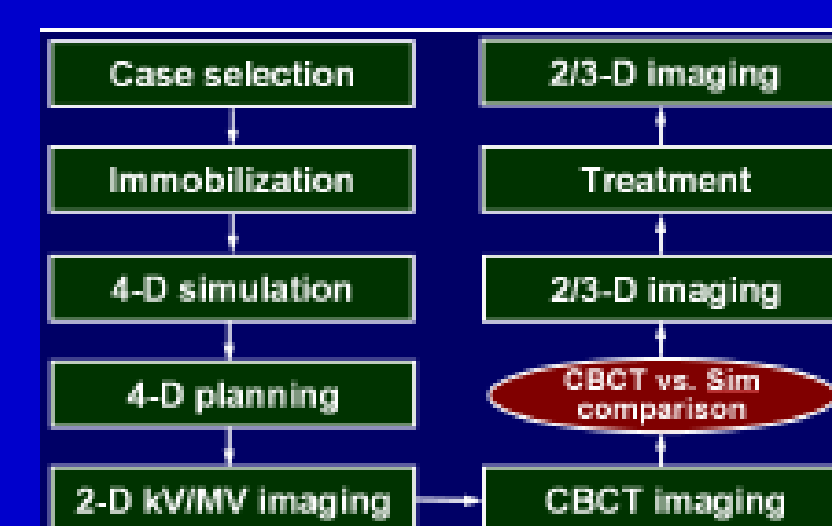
Protocol for CBCT-guided SBRT.
